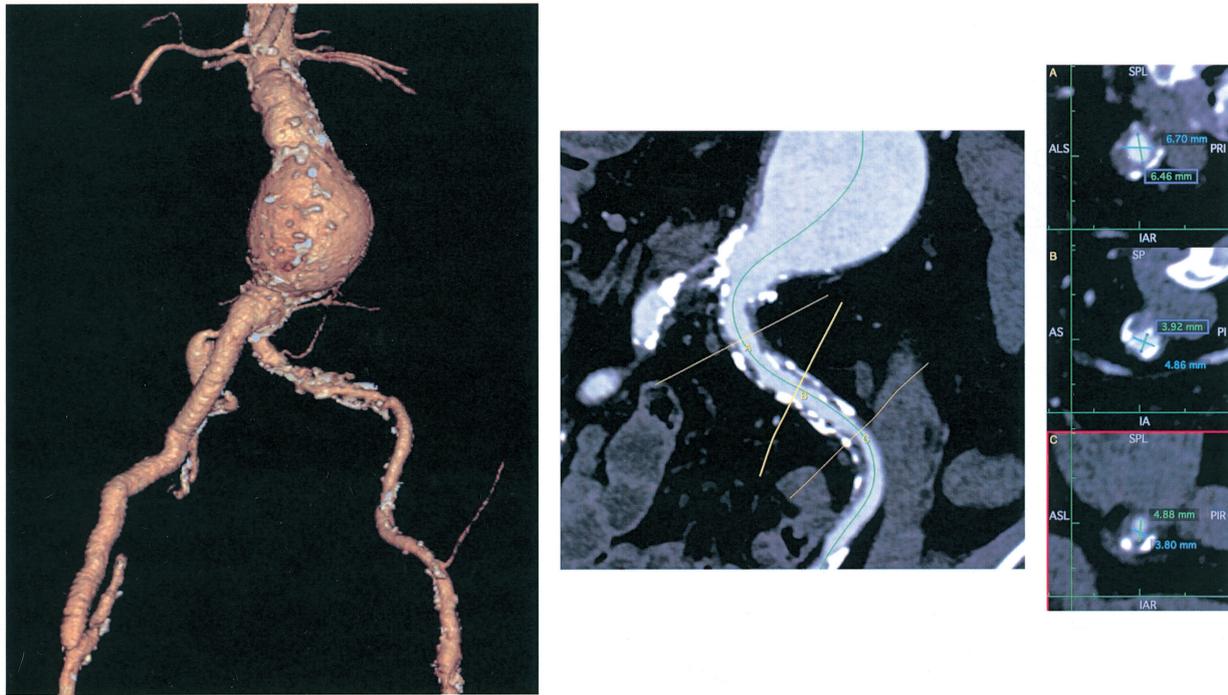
Left figure; Preoperative reconstruction of computed tomography angiogram revealed the infrarenal abdominal aneurysm and aortofemoral bypass. Right two figures; The multi-planar reconstruction computed tomography showed the left iliac artery was narrowed with heavy calcification throughout its length.
